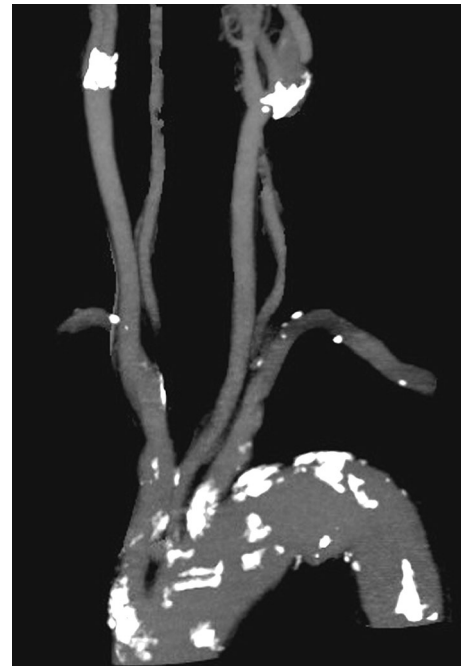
Sample of the multidirectional maximum-intensity-projection reconstruction image obtained by multi-detector computed tomography angiography (MDCTA). This case had severe calcification in the aortic arch, the orifices of the aortic arch branches, and the origins of the bilateral internal carotid arteries
